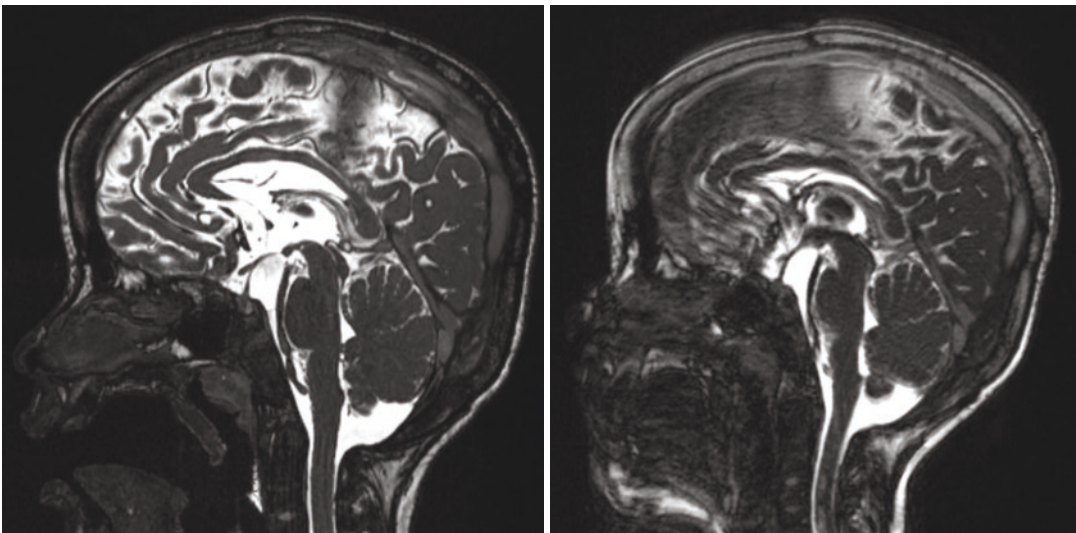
Post-operative MRI for case 2
